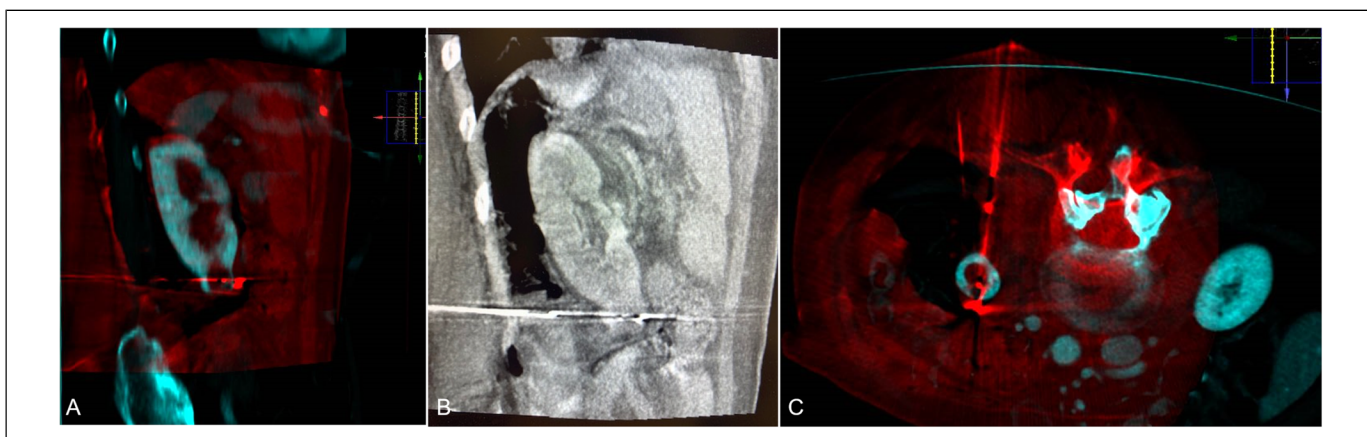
Fusion image obtained after air dissection to sunder the kidney from the colon (A); contrast-enhanced CBCT obtained to check the correct position of the antenna: coronal (B) and axial view (C).
